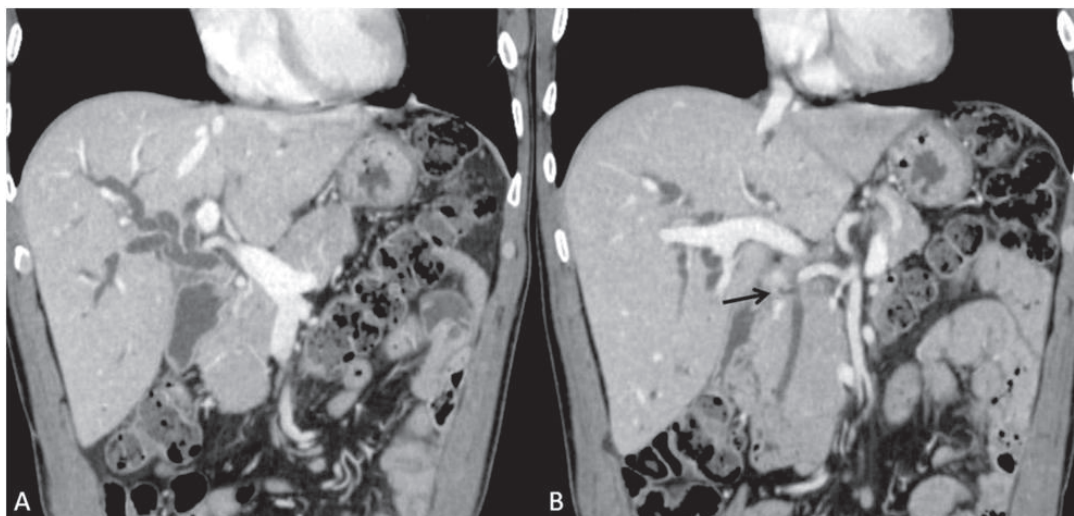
Coronal reconstructed CT image reveals bilobar intrahepatic biliary radicle dilatation and proximal common duct dilatation with an enhancing soft tissue lesion obstructing the common duct seen in close proximity with the cystic duct stump (arrow in fig 1B).
